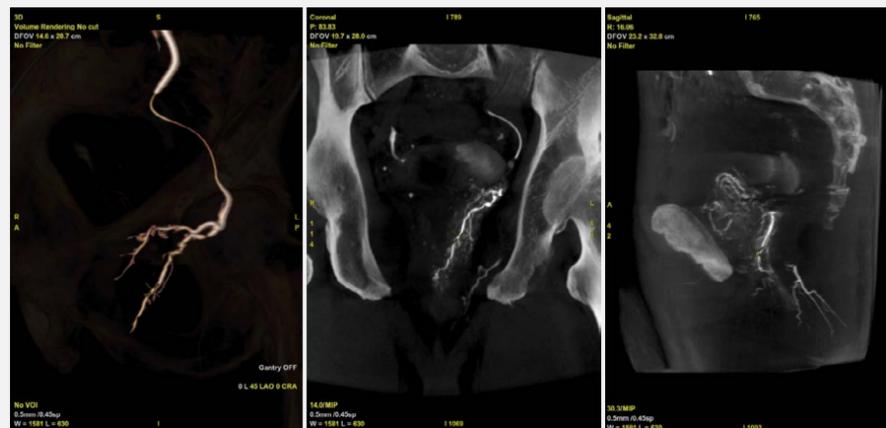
57 years old male patient. Left: 45° ipsilateral DSA showing vessels overlap hiding the prostatic artery's origin. Right: CBCT imaging depicting the ostia of the prostatic artery (classified in this case as Type 1 anatomical variant<sup>6,7</sup>).
